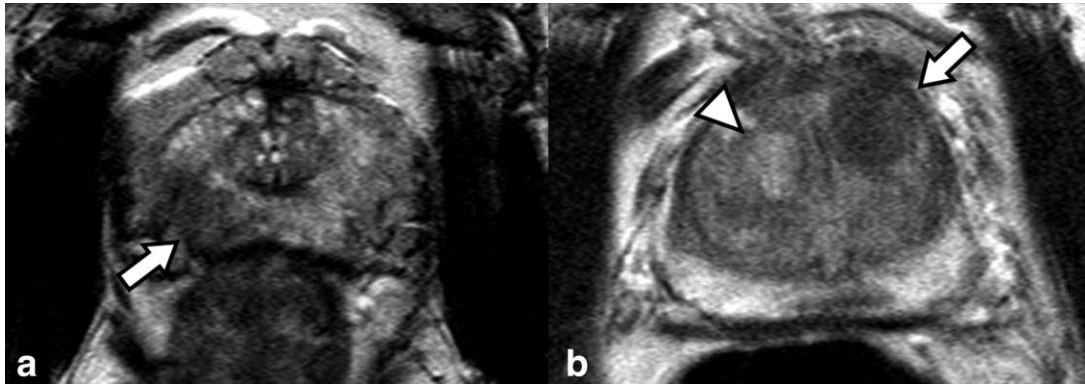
Typical cases of prostate cancer (arrow in a), stromal benign prostatic hyperplasia (BPH) (arrow in b), and nonstromal BPH (arrowhead in b) on T2-weighted images. Prostate cancer shows ill-defined hypointense lesion on T2WI, while stromal BPH and nonstromal BPH show well-defined hypointensity and hyperintensity on T2WI, respectively.
